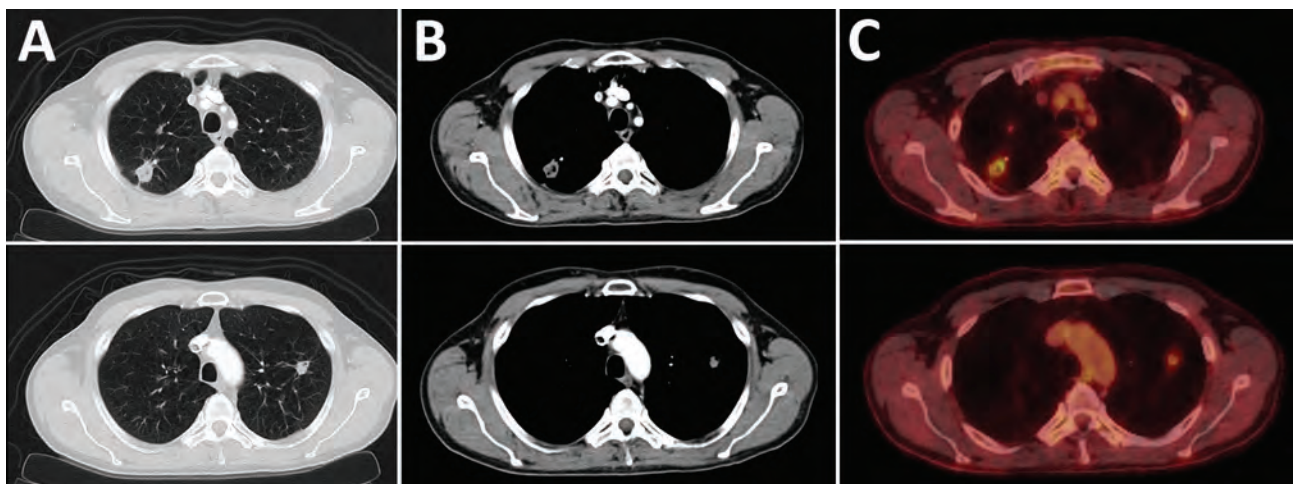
High-resolution computed tomography and 18F-fluorodeoxyglucose positron emission tomography scans of the chest showing pulmonary lesions caused by *Mycobacterium hassiacum* in a 62-year-old man, Austria. A and B) Computed tomography scans of the chest showing a subpleural thick-walled cavitary lesion in the posterior segment of the right upper lung lobe with associated pleural thickening and a smaller adjacent partly calcified solitary nodule. Another solid nodule of 13 mm diameter was found in the left upper lung lobe. C) Positron emission tomography scan showing a tracer uptake in both lesions with a standardized uptake values of 5 (top image) and 1.9 (bottom image).
